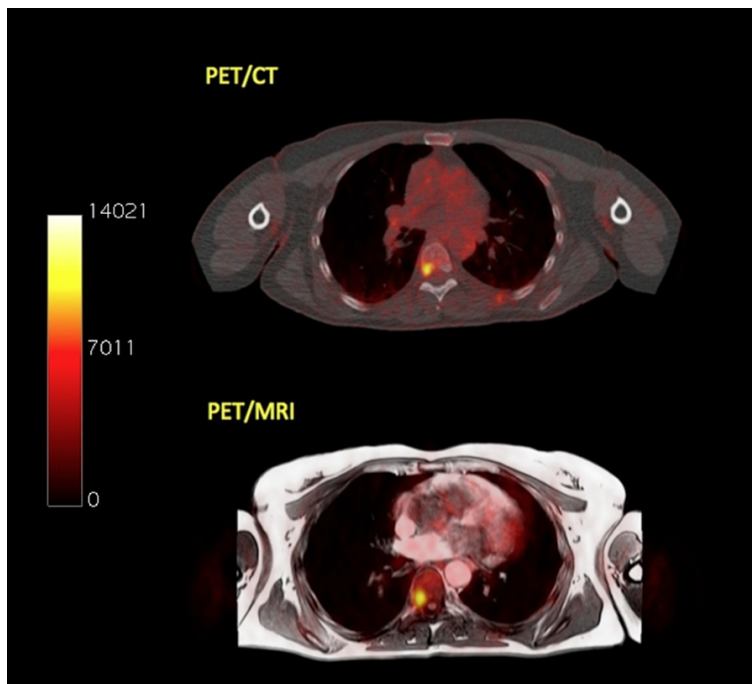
Transaxial PET/CT (upper row) and PET/MRI (lower row) images of the same patient as in Figure 2. The patient has a myeloma-indicative site of enhanced ^{18}F -FDG uptake in the 7th thoracic vertebrae seen with both hybrid imaging systems. The lesion has the following values in PET/
